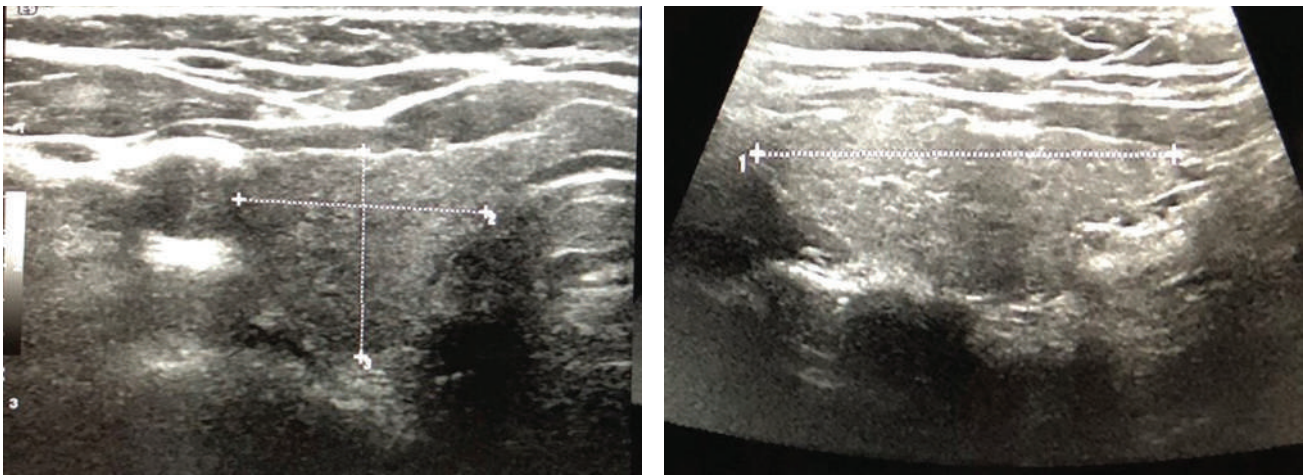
Ultrasound of the right thyroid lobe: The right lobe measured 3.3 x 2.0 x 1.0 cm, with x 10 magnification.
